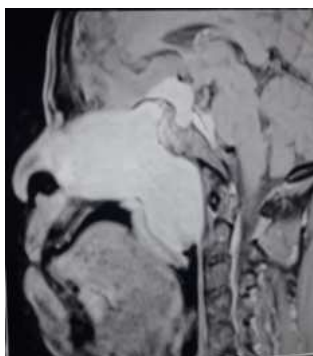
MRI Brain with PNS in sagittal view
